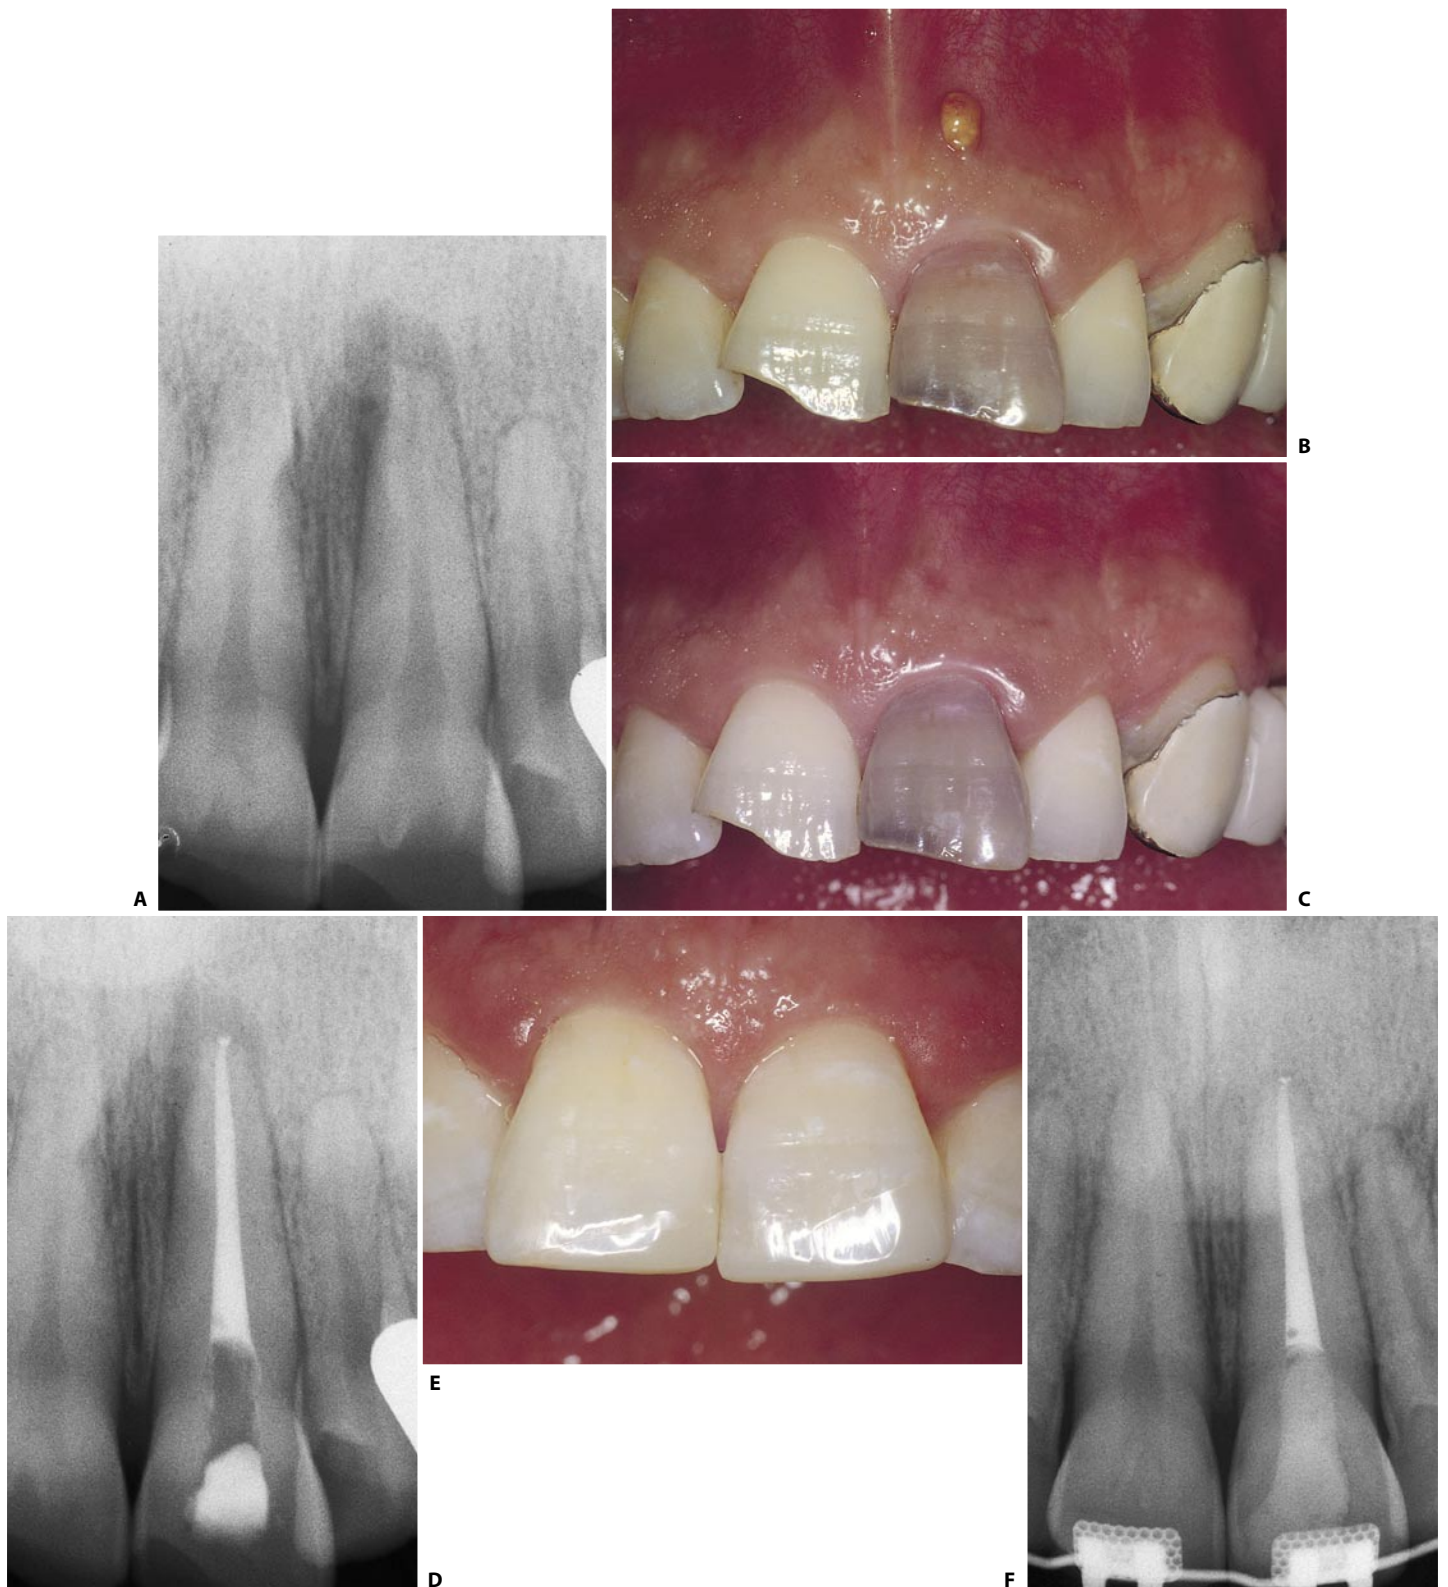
A. Preoperative radiograph of the upper left central incisor with a necrotic pulp caused by preceding trauma. B. The dental crown is strongly discolored by hemorrhage secondary to the trauma. Note the mucosal fistula. C. One week following the cleaning and shaping procedure only, the fistula has completely disappeared. D. Postoperative radiograph: the filling has been performed after determining clinically that the fistula had healed. E. Appearance of the dental crown after bleaching. F. One year recall.
